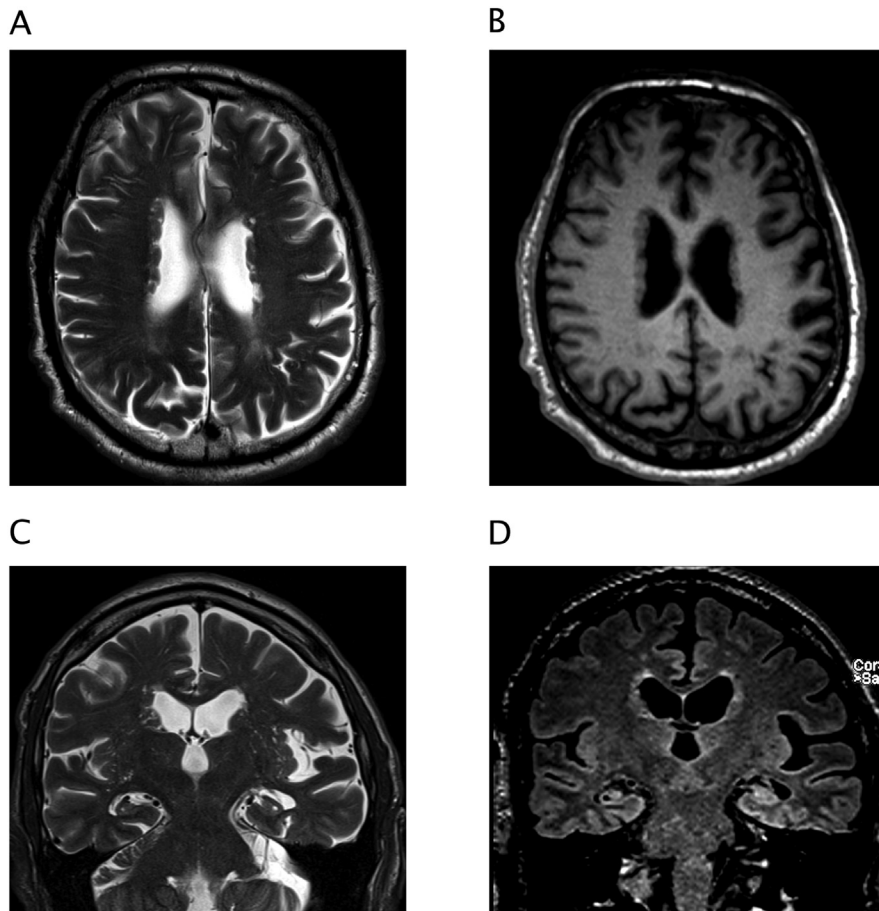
MRI showing bilateral symmetric periventricular nodular heterotopia and bilateral hippocampal atrophy more pronounced on the left. In A) T2-weighted and B) T1-weighted images of the nodules that are isointense to cortical gray matter, adjacent enlarged perivascular spaces showing a T2-hyperintense cystic appearance. C) Coronal orientated T2-weighted images revealing hippocampal atrophy and disruption of the internal hippocampal structure on both sides. D) FLAIR-images supplementing these findings with hyperintense signals present in both hippocampi.
